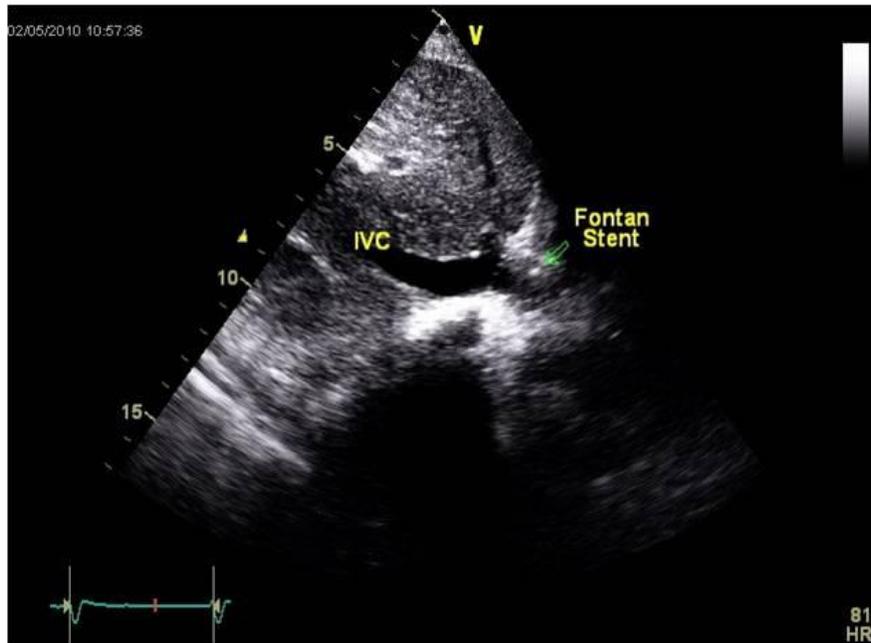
Two-dimensional echocardiographic image showing the proximal part of Fontan stent in second patient
